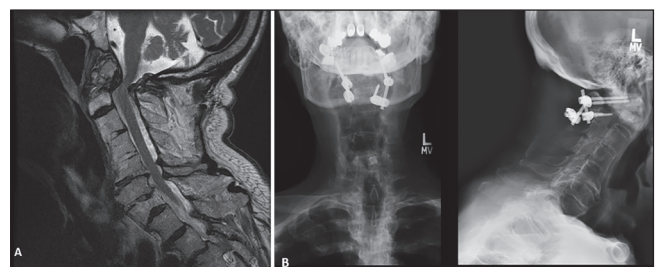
Patient fell a 2<sup>nd</sup> time. (a) Sagittal T2-weighted images showing circumferential cord compression. (b) The patient underwent C1 posterior arch resection, bilateral C2 neurectomies, and C1-2 posterior instrumented fusion, with the postoperative result shown in sagittal and anteroposterior X-ray
